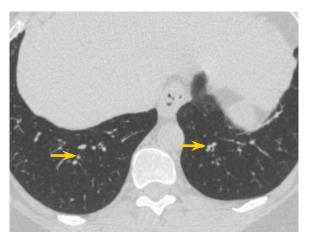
A sample axial CT image in a patient with severe asthma, which is focused on the basilar segments, shows foci of endobronchial mucus impaction (yellow arrows).
